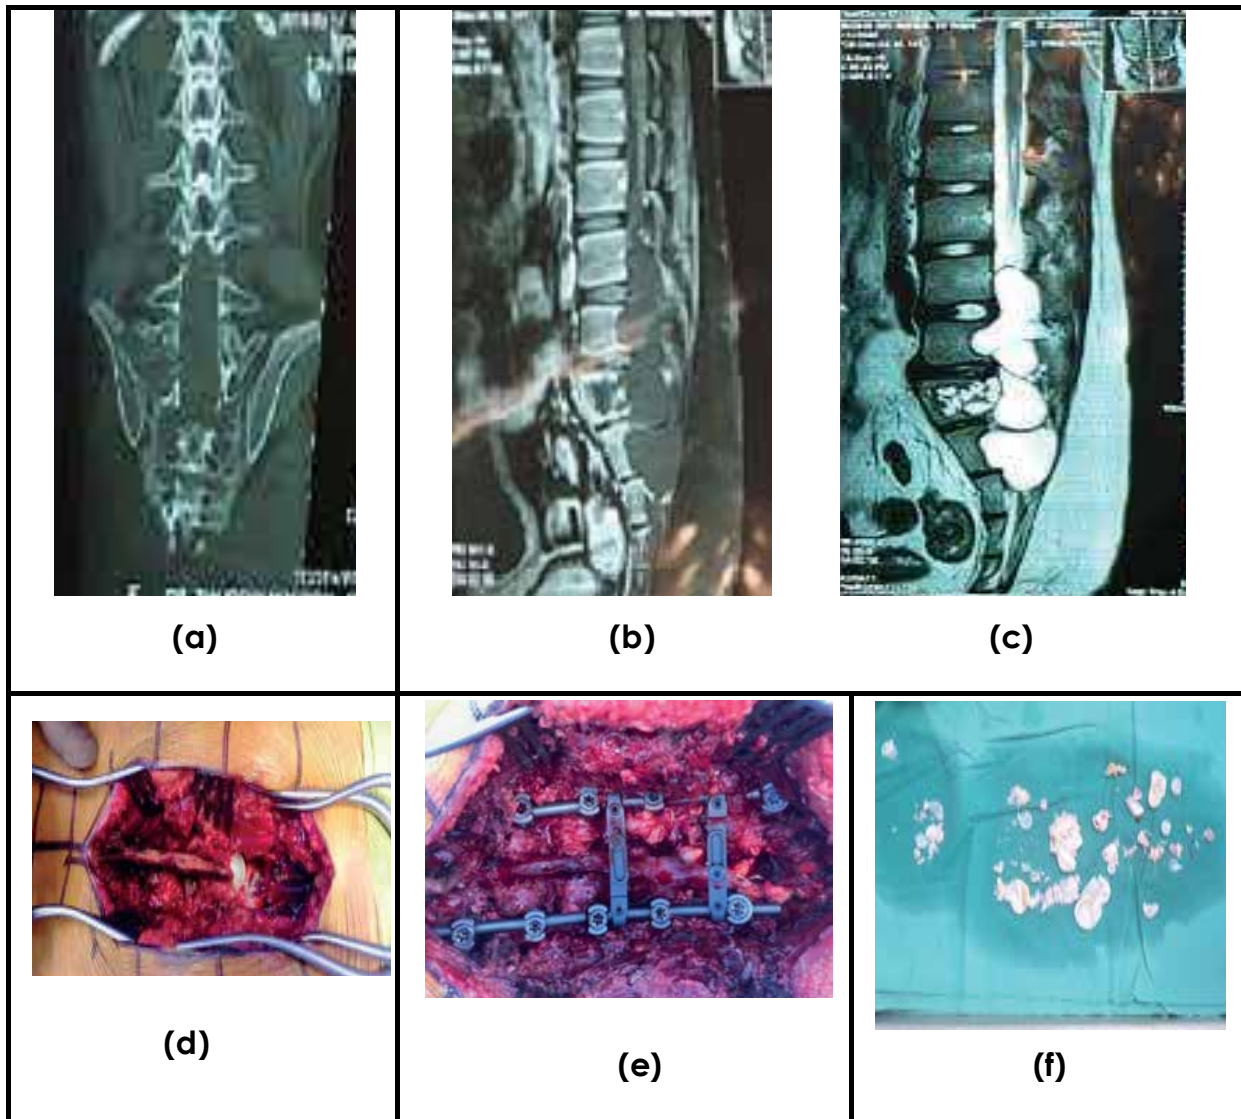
(a) Coronal cuts of CT scan showing involvement and extent of cyst in lumbosacral spine, also involving the right side sacrum (b) Sagittal cut of MRI T-1 image – showing dark signals around the involved area, as CSF and fluid appears dark. Sagittal cut of MRI (c) T-2 image – showing high uptake along posterior border of L3-S1 also involving vertebral body of S1 (d, e) Perioperative images of cyst and fusion surgery (f) Postoperative removed cyst.
